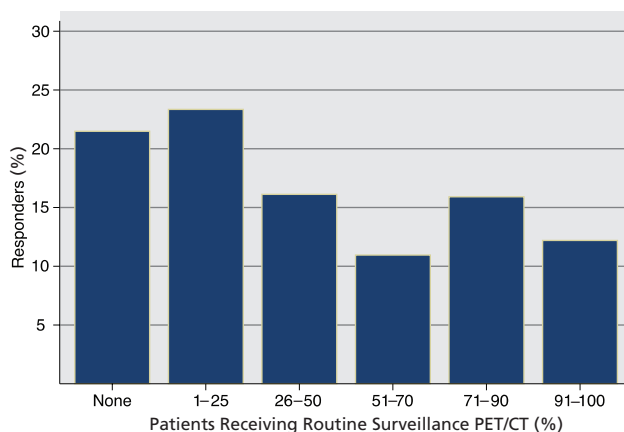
Self-reported use of PET/CT for routine surveillance imaging in asymptomatic patients. After a single clinical scenario, physicians were asked, "What percentage of your patients with head and neck cancer received routine surveillance PET/CT scans?" Those who answered more than "none" were ever-users. Those who answered $\geq 51\%$ were high-imaging users. There were 484 responses to this question.
